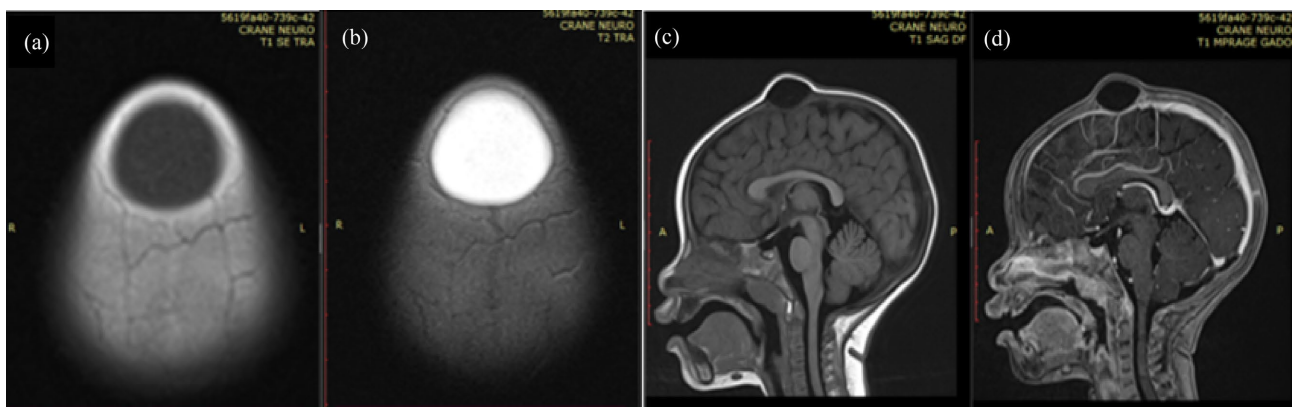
Cranioencephalic MRI: over the anterior fontanelle, a well-defined cyst appears hypointense on T1-weighted image (a); hyperintense on T2 (b); no intracranial extension (c); and no enhancement after contrast injection (d).
